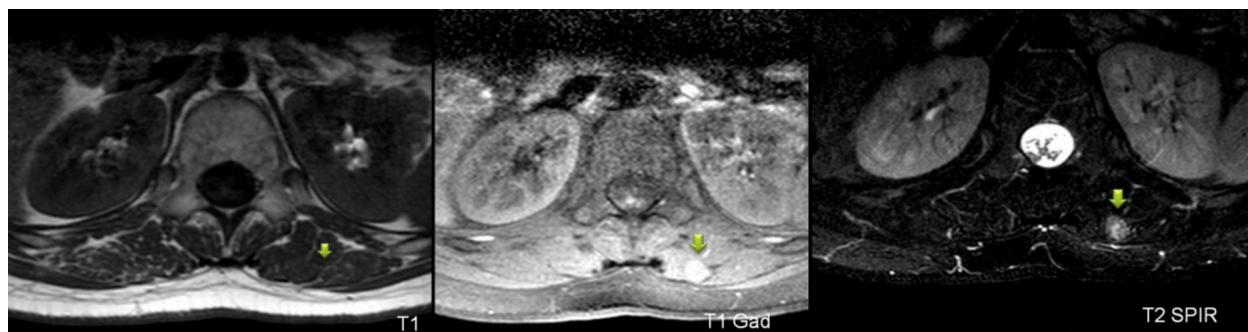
Spinalis muscle fibromatosis in a 59-year-old female. MR images showing a well defined nodular lesion (arrows) in the left spinalis muscle with isointense to muscle signal on T1-weighted images, faint hyperintense signal on T2-weighted images with fat saturation and avid contrast enhancement.
